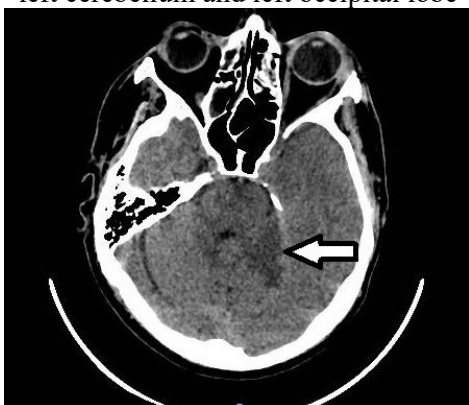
Computed Tomography - parcellarischemias in the left cerebellum and left occipital lobe
